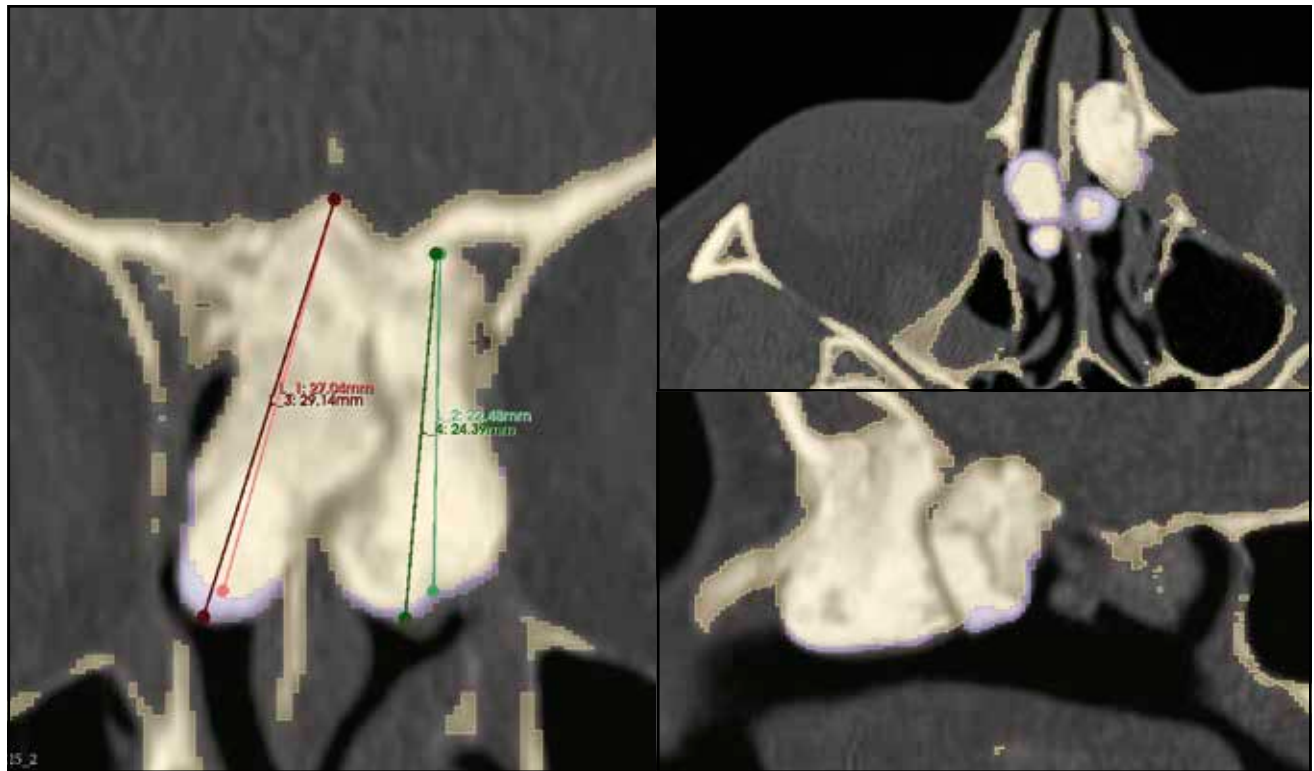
High-resolution cranio-facial CT scans (coronal, axial, sagittal): Highlights of the osteoma showing initial dimensions at presentation (yellow shading) and evolution after 1 year (purple shading).
